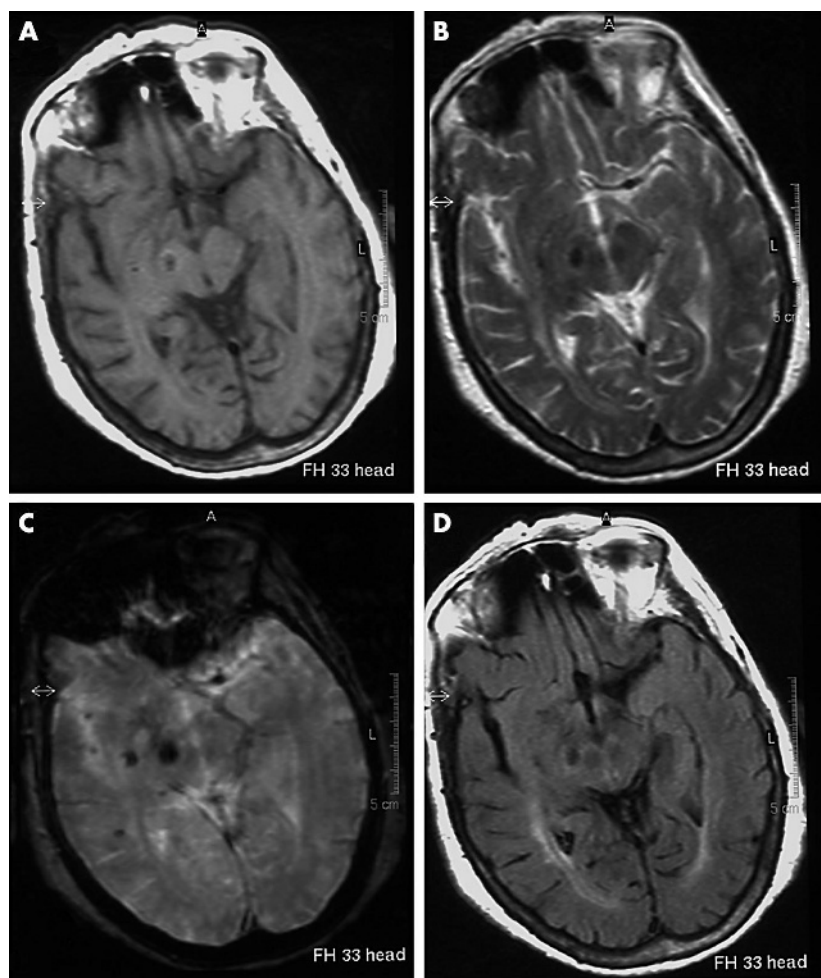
MRI of the brain of the patient. (A) Axial SE T1-weighted image (TR 582/TE 1.5). (B) Axial TSE image (TR 2200/TE 120). (C) Axial GE T2-weighted image (TR 600/TE 23). (D) Axial T2-FLAIR image (TR 6000/TE 100/TI 2000). The images show a subacute haemorrhagic lesion in the midbrain of the right side.
